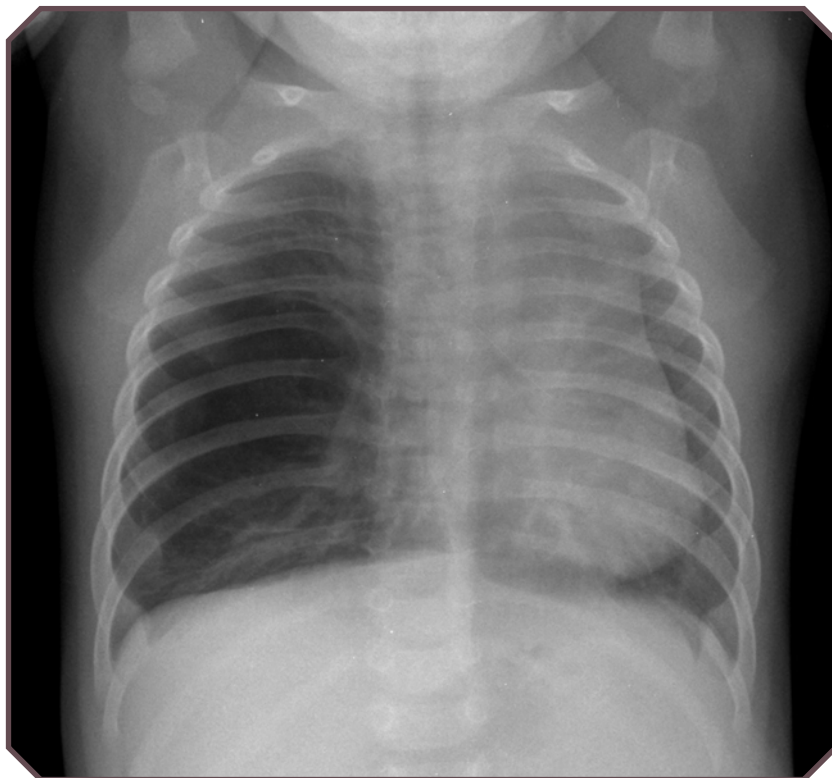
Type 1 congenital pulmonary airway malformation incidentally identified in a 3-month-old full-term male infant with a cough. Posteroanterior chest radiograph demonstrates hyperlucency of the right hemithorax, with right to left midline shift. Image courtesy of Robert Paul Guillerma, MD, Pediatric Radiology, Texas Children's Hospital.
